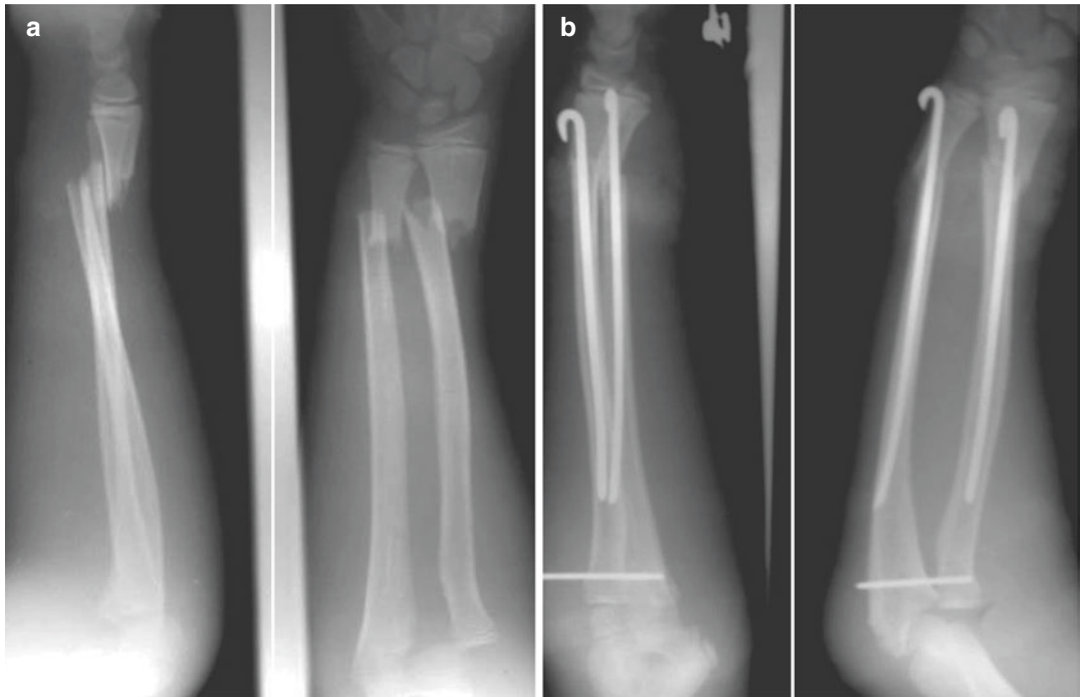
(a) X-rays of a distal radius and ulna fracture with dislocation of proximal radius (Monteggia variant) was (b) initially treated by open reduction and nailing. The patient developed an infection which was (c) treated
